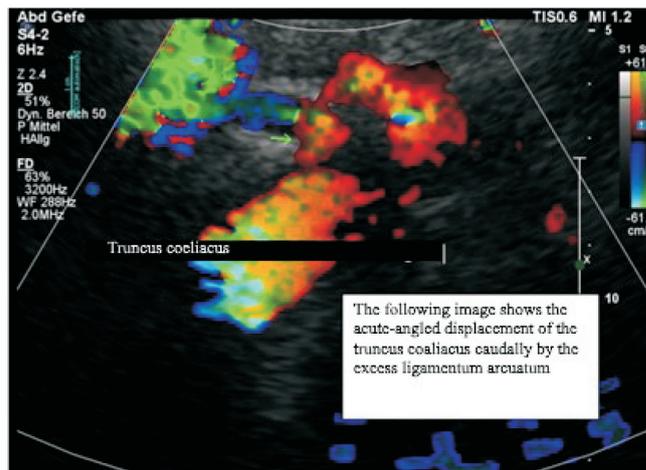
Dunbar syndrome colour Doppler sonography of presented patient.
